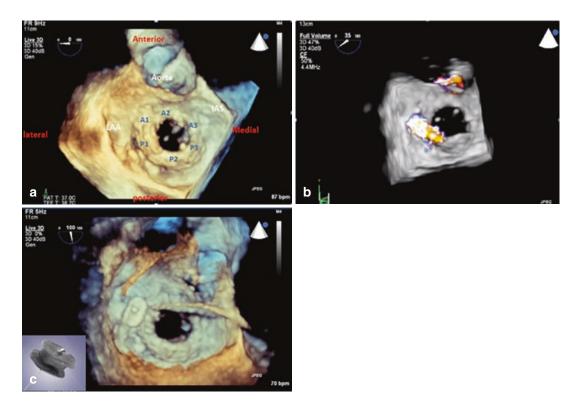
Mitral paravalvular leak in the lateral (9 o'clock) position on: (a) 3-dimensional transoesophageal echocardiography, (b) with colour flow Doppler, (c) after device closure (inset shows the occluder device)
